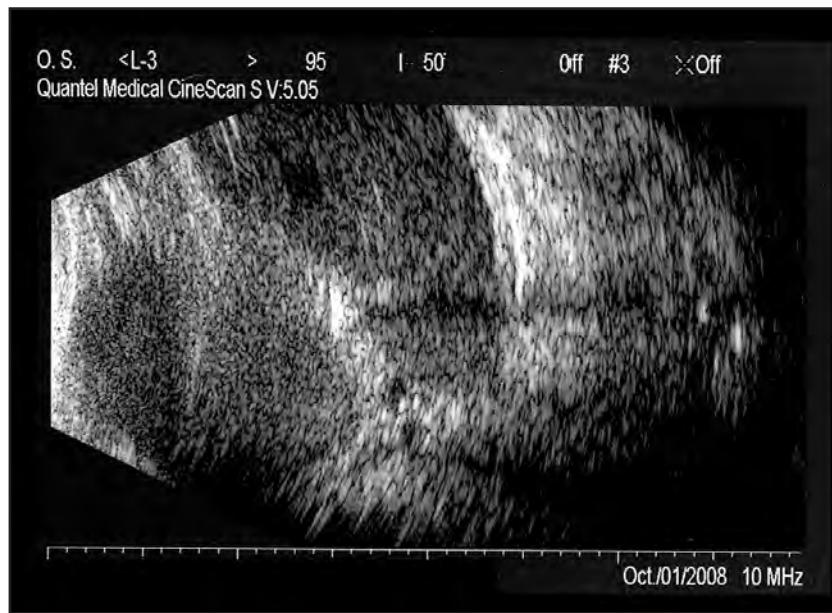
Ultrasound B-scan showing an appositional suprachoroidal hemorrhage, and the presence of an intraocular foreign body with acoustic shadow between the two dome-shaped lesions.
